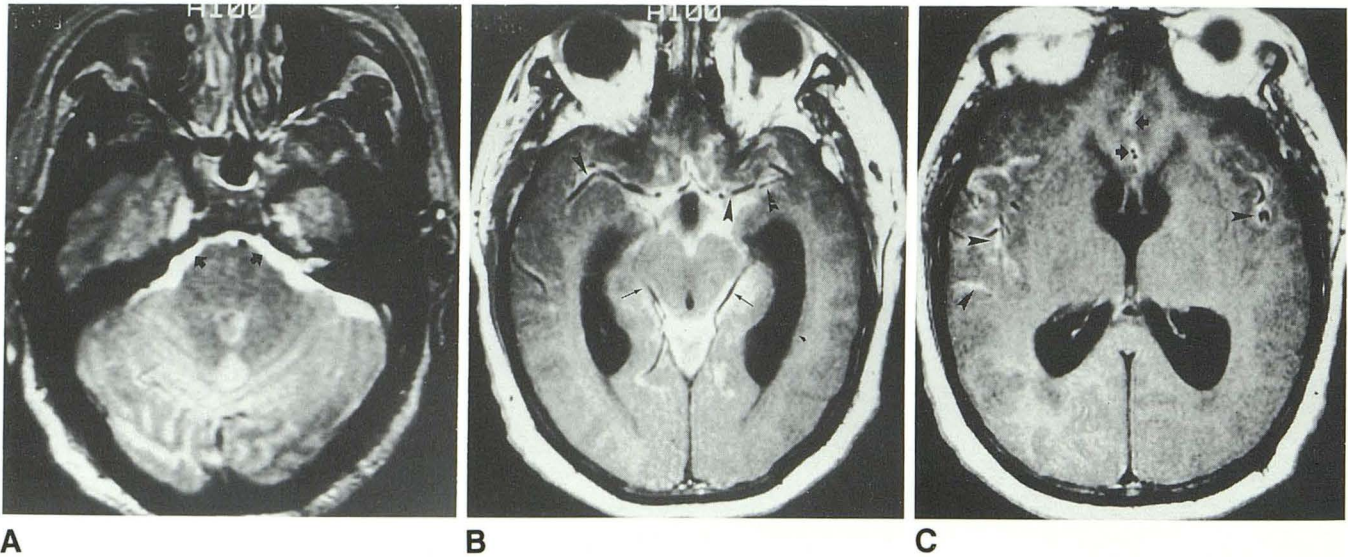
Patient 6; 53-year-old man admitted for evaluation of dementia. Proton density (3000/30) axial images (A) show abnormal signal in the prepontine and cerebellopontine cisterns (arrows). B and C, Gd-DTPA-enhanced T1-weighted (600/20) images show sylvian (arrowheads), perimesencephalic (small arrows), and interhemispheric (large arrows) enhancement and acute hydrocephalus.
